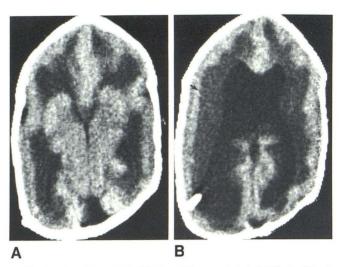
Case 6 (case 1 in [2]). Type II lissencephaly in WWS. A, CT scan at 5 months. B, Higher cut. Typical manifestations of type II lissencephaly. This patient had congenital noncommunicating hydrocephalus and was shunt-dependent. Smooth subsurface line (*arrow*).
